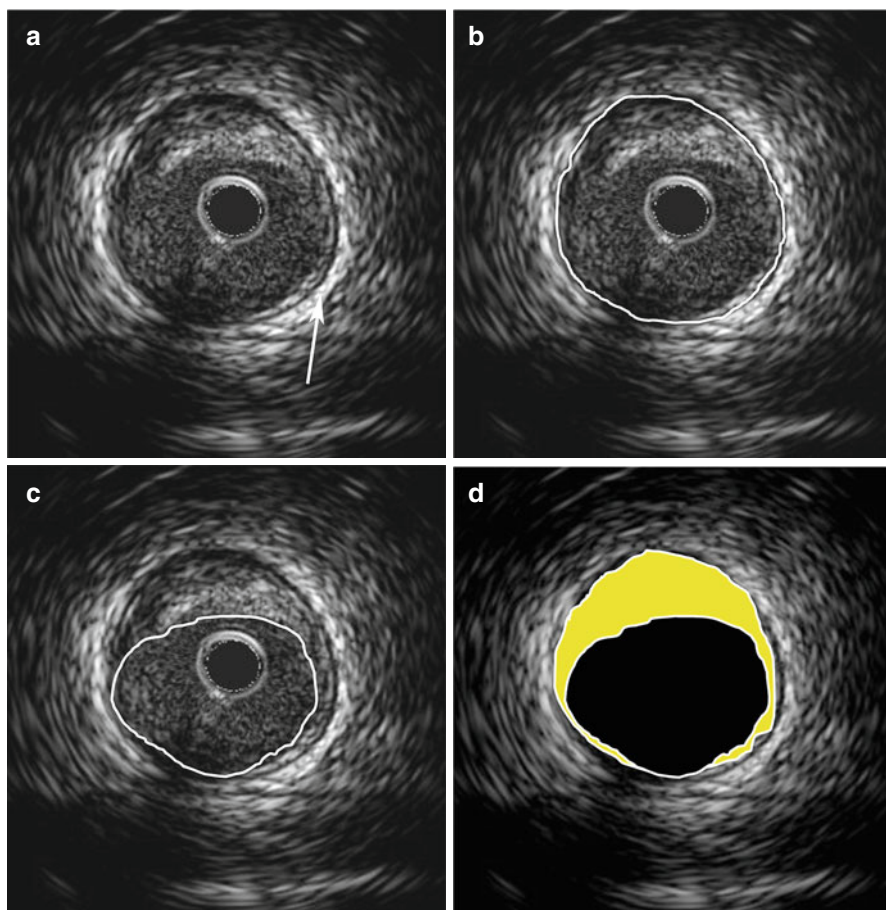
Coronary artery intravascular ultrasound. An example of single cross section of a segment of the left anterior descending coronary artery obtained by intravascular ultrasound (IVUS) showing a fibro-fatty plaque (a). The external elastic lamina is shown by the *arrow*. The method of measuring plaque area is demonstrated. First, the external elastic lamina is identified and the area is traced (b); similarly, the lumen area is traced (c). The plaque area for this cross section is defined as the (EEL area) – (lumen area) (d). Plaque volume is determined by the summation of the individual plaque areas (Used with kind permission of Springer Science + Business Media from Ragosta [13])
